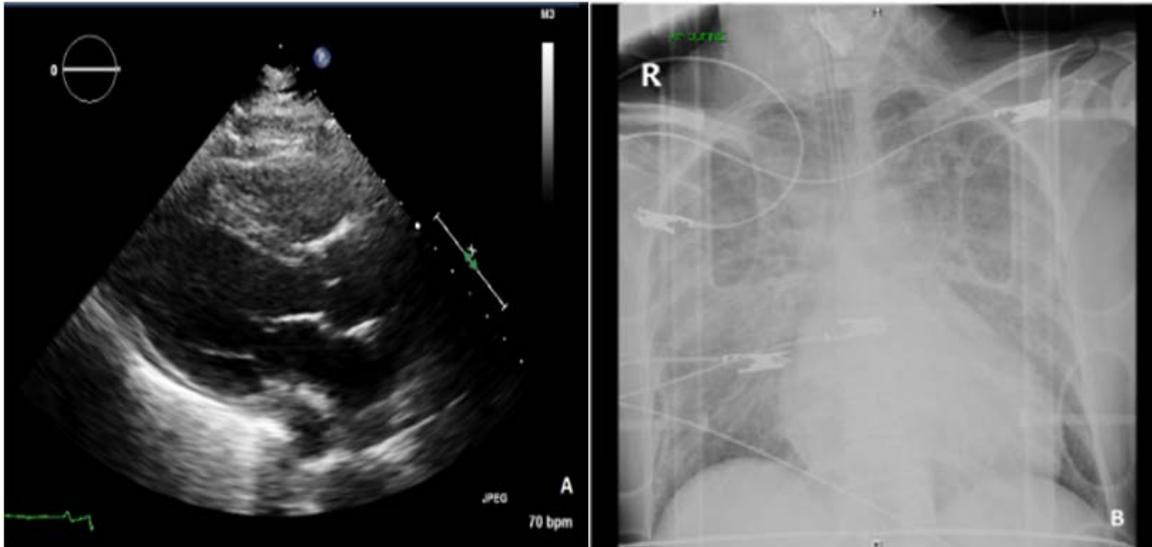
Echocardiographic parasternal long axis revealing severe global left ventricular dysfunction with an estimated ejection fraction of 25-30%. Figure B. Anteroposterior chest radiograph showing pulmonary edema
